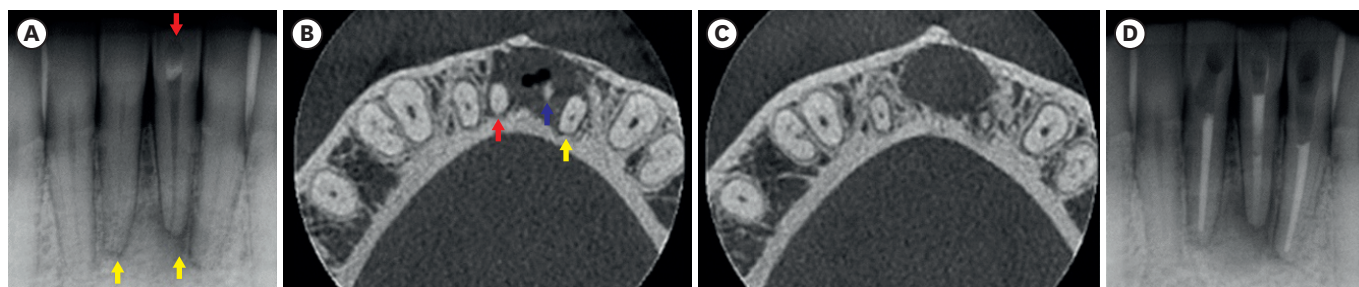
Images referring to the first phase of the treatment (diagnosis and completion of the endodontic interventions). (A) Initial periapical radiography. Red arrow: tooth #31 with previous root canal access and periapical lesion. Yellow arrows: teeth #32 and #41 with apical periodontal ligament space thickening. (B and C) Initial cone-beam computed tomography images (axial view). Large periradicular lesion affecting the anterior region of the mandible and the root apices of teeth #31 (blue arrow), #32 (yellow arrow), and #41 (red arrow). (D) Final periapical radiography, with teeth #32 and #41 filled with gutta-percha and endodontic sealer, and tooth #31 filled with mineral trioxide aggregate.
